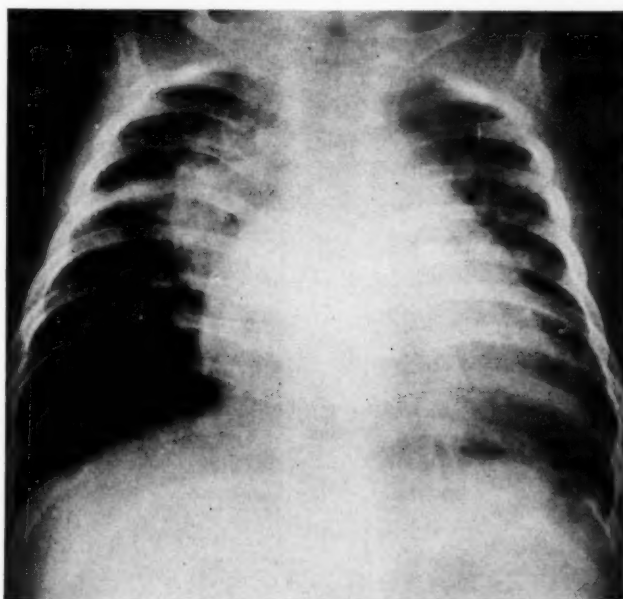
Posteroanterior roentgenogram of the thorax.
